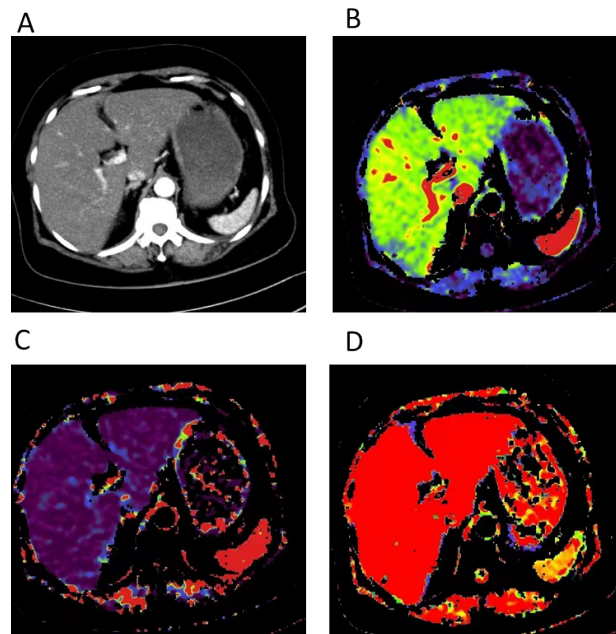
Plain and enhanced CT images of A patient with hepatocellular carcinoma (A) The original image showed A huge lesion in the right lobe of the liver with significantly uneven enhancement. (B) HAC images showed heterogeneous hyperperfusion. (C) PVC images showed hypoperfusion. (D) AEF images showed heterogeneous hyperperfusion throughout the lesion.
